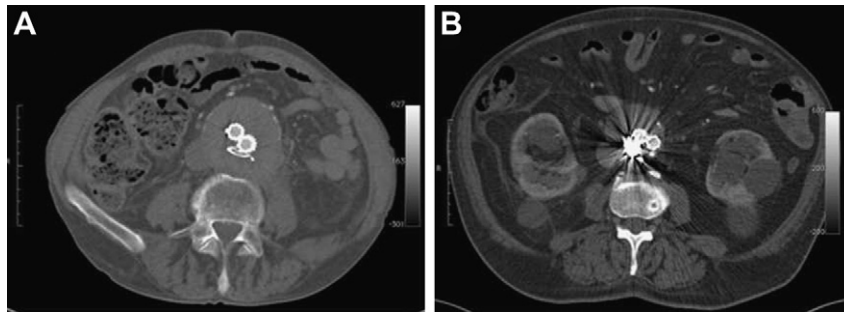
Axial computed tomography (CT) angiogram images of aortic aneurysm sacs after endovascular aneurysm repair (EVAR) with aneurysm sac embolization using (A) Tornado MR eye coils and (B) platinum coils.
